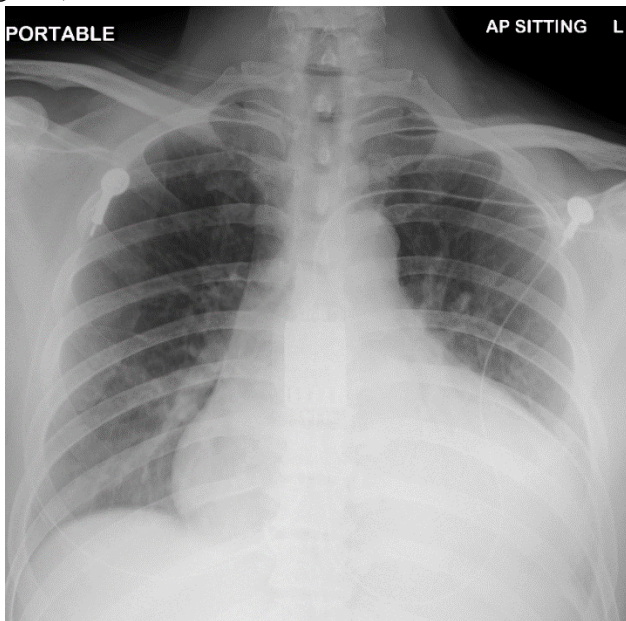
Chest radiograph showed persistent opacities over left retrocardiac region. Interval increased in cardiomegaly.
